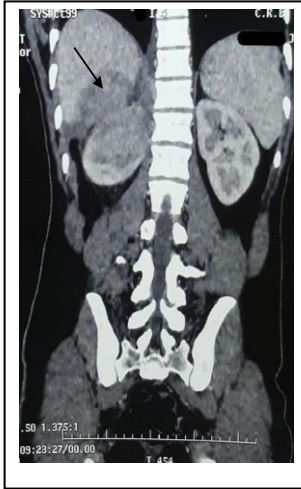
Abdominal CT scan showing an upper polar renal tissue mass invading the right adrenal gland and the lower border of the liver (arrow).
